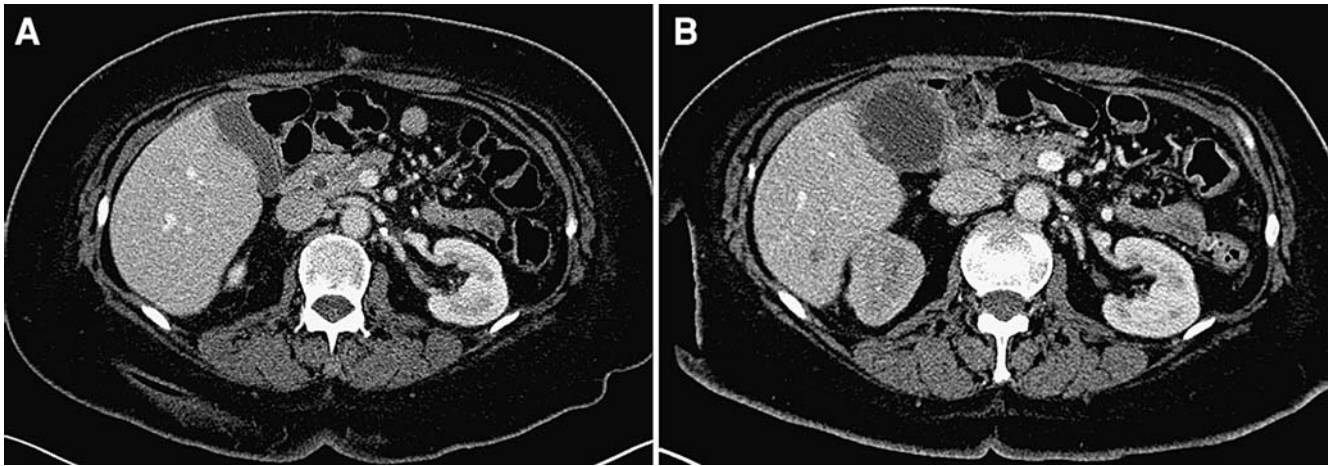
(A) In a different patient than in Fig. 16, pre-treatment contrast-enhanced CT demonstrates a normal gallbladder. (B) Post-treatment contrast-enhanced CT demonstrates a small amount of pericholecystic fluid and an abnormally thickened enhancing gallbladder wall—findings
